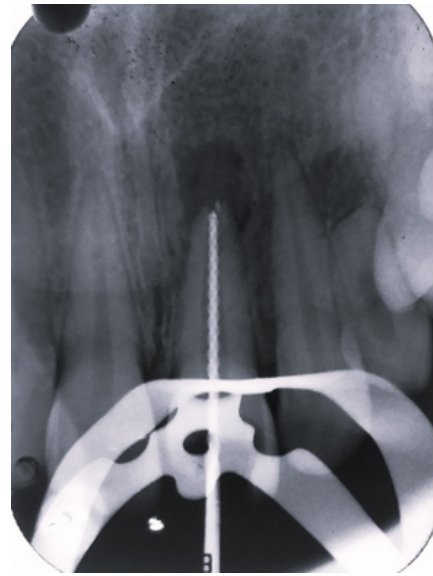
Working length determination with radiographic method
